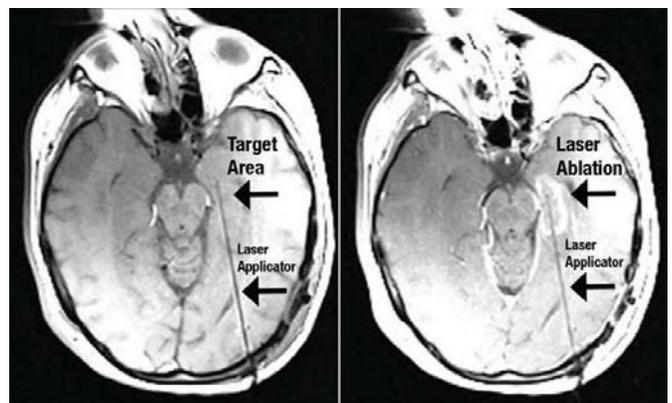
MRI guided laser ablation
